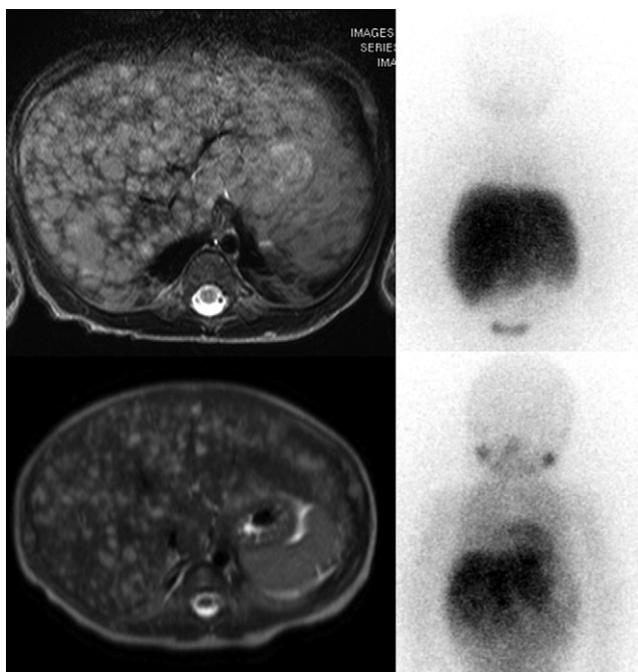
Neuroblastoma stage 4S. MRI (top left) in a 3-month-old infant confirms a markedly enlarged liver with multiple solid lesions. The initial ^{123}I -MIBG study (top right) shows marked increased uptake of tracer in the liver, confirming neuroblastoma. Note almost no distribution of MIBG in the normal distribution areas, including the myocardium. After chemotherapy, there was marked shrinkage of the liver. MRI (lower left) shows marked improvement but still abnormal. The ^{123}I -MIBG study (lower right) shows patchy increased uptake in the liver and the biodistribution of the tracer now shows normal uptake in the myocardium and salivary glands. Later follow-up studies were within normal limits.
